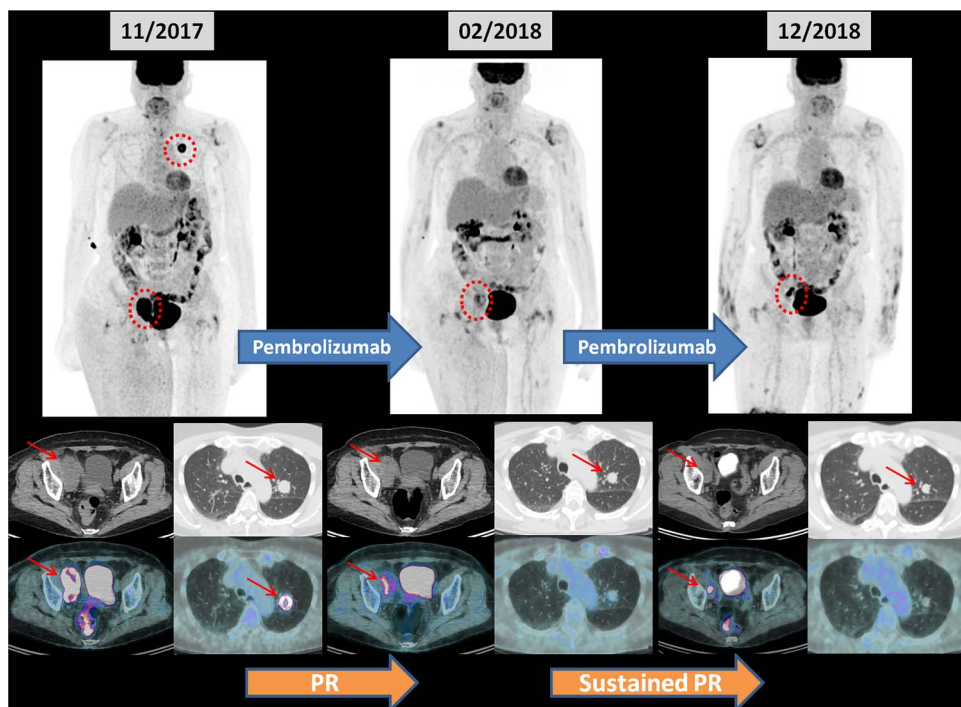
FDG PET/CT scans during treatment demonstrating partial response in the first response assessment scan (after 3 cycles) characterized by complete metabolic response in the pulmonary nodule (dashed circle) and partial metabolic and morphologic response in the right pelvic lymph node enlargement (red arrow in D). These findings had similar and sustained partial response in following scan (after 18 cycles) as shown in image C.
